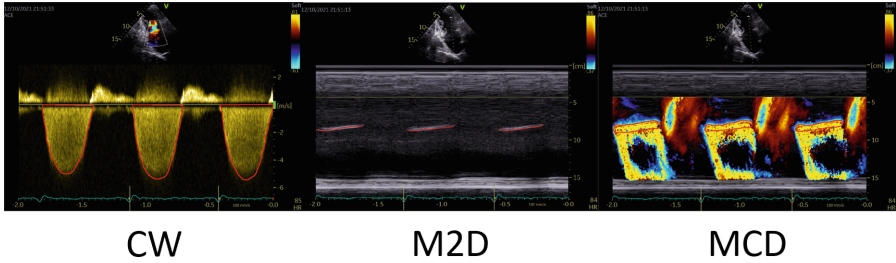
Examples of the multi-channel ultrasound images, (1)continuous wave Doppler images (CW) are used to capture the blood velocity; (2)two-dimensional M-mode ultrasound images (M2D) provide the lower bound of the PISA radius; (3)M-mode color Doppler images (MCD) provide the upper bound of the PISA radius.
